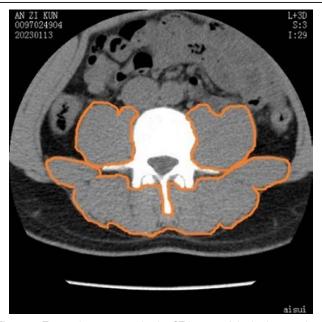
Twenty-three years male, the CT images of the lumbar vertebrae 3 (L3), the total cross-sectional areas of the psoas major and paravertebral muscles. CT = computed tomography.
